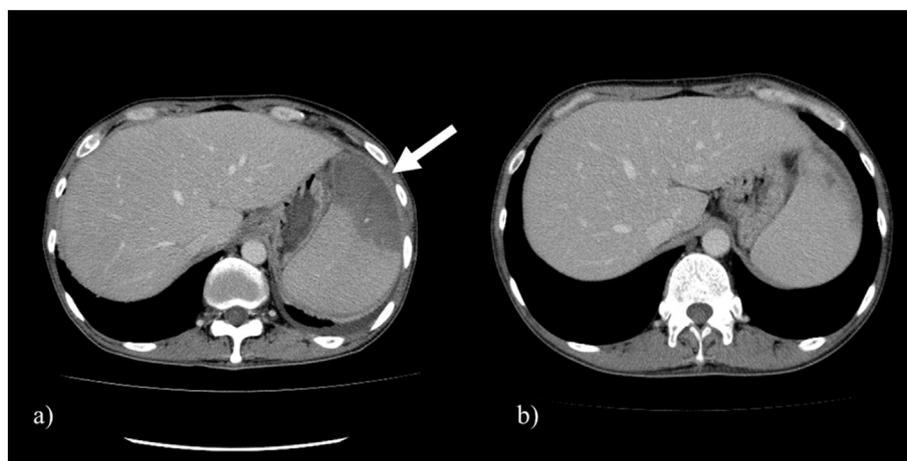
Abdominal CT, a; Splenic infarction detected as a hypo-enhanced area in CT on 84 days after admission (arrows). b; Splenic infarction was improved in follow-up CT after discharge.
